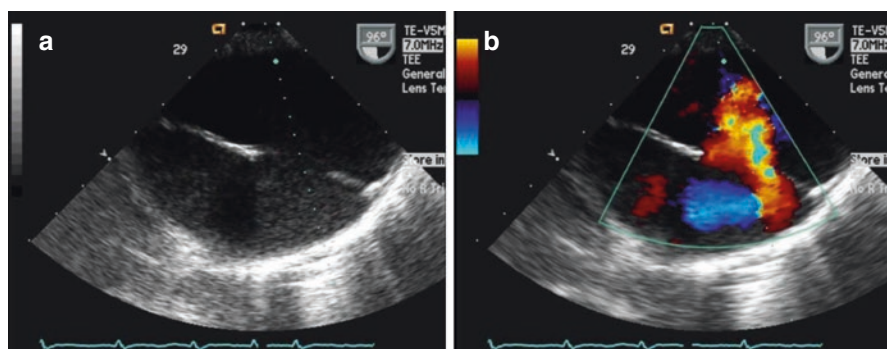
A dissection flap is seen in the descending thoracic aorta separating the true and false lumens; the site of intimal tear is represented by the flow from the true lumen into the false lumen on color Doppler
